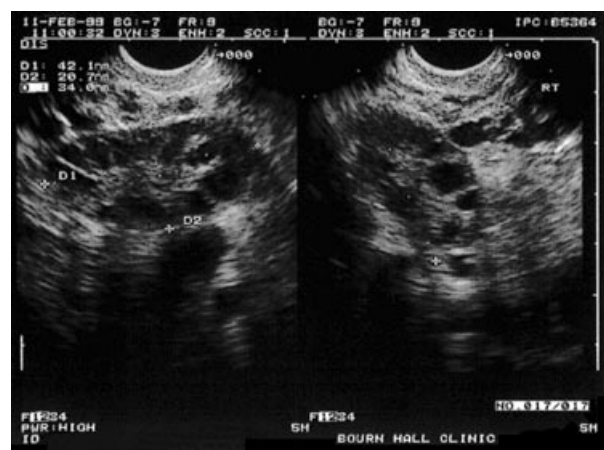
Transvaginal ultrasonography of right and left normal ovaries (Upper), non-enlarged polycystic ovary (Middle) and enlarged polycystic ovary (Lower). The ovaries were measured in three planes and ovarian volume was calculated using the prolate ellipsoid formula. Ovarian volume (V) = $D1 \times D2 \times D3 \times 0.523$. D1, D2 and D3 are the three maximal longitudinal, antero-posterior and transverse diameters respectively. Ovarian volumes: Upper = $0.523 \times 3.08 \times 1.7 \times 2.48 = 6.79 \text{ cm}^3$; Middle = $0.523 \times 3.37 \times 2.07 \times 2.81 = 10.25 \text{ cm}^3$; Lower = $0.523 \times 4.21 \times 2.07 \times 3.4 = 15.5 \text{ cm}^3$.
